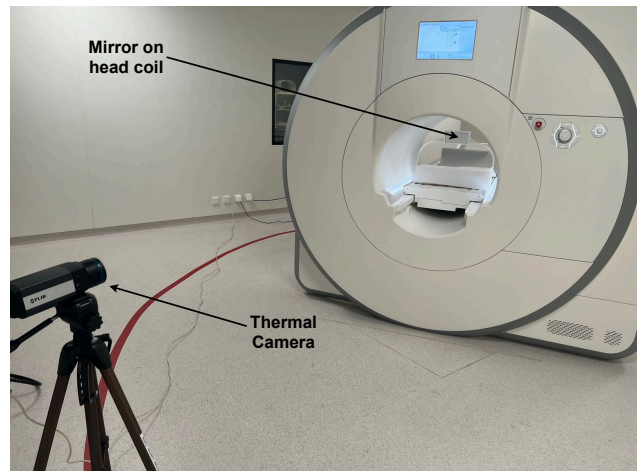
Thermal camera set behind the MRI machine and the subject. The camera is aimed at a mirror fixed on the head-coil which allows the heat signal of the ROI to bounce back into the camera while the subject is lying down.
